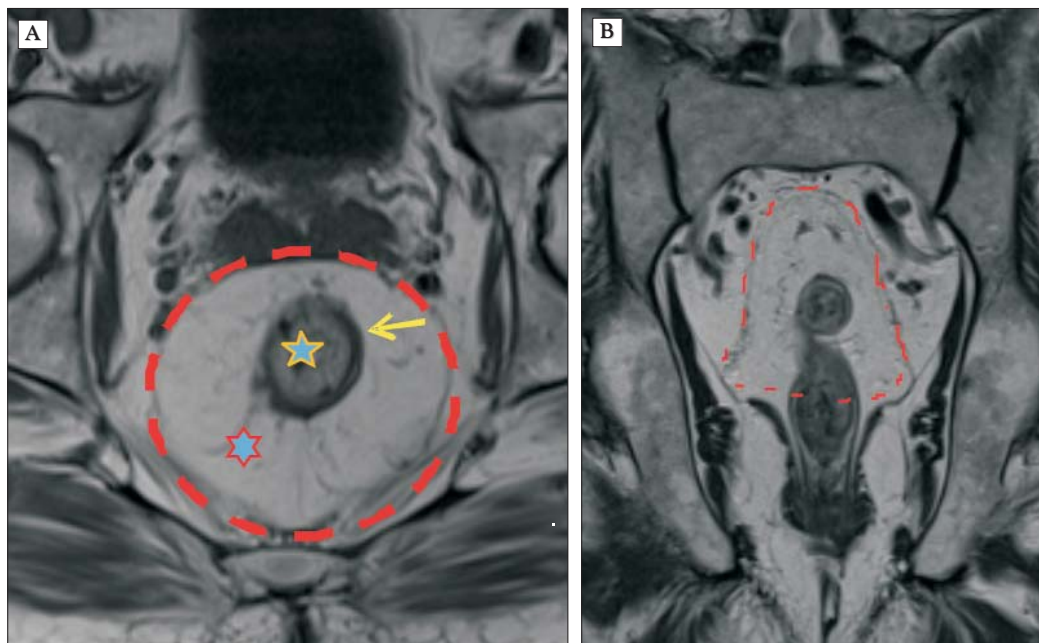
MRI sequence in T1 with sections (A) paraxial and (B) paracoronal. The circumferential resection margin (CRM) is the mesorectal fascia, marked with a discontinuous line. We can see the rectal wall (arrow), a tumour (yellow star) and the mesorectum (red star).
